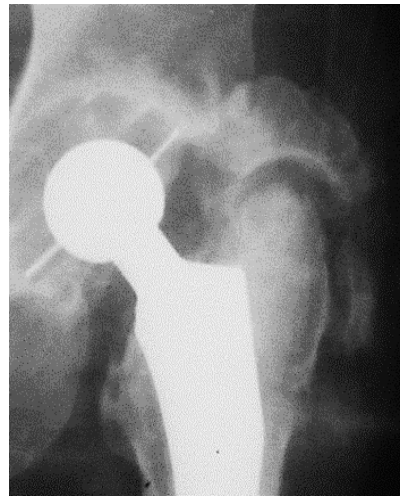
Left hip X-ray showing 3rd degree heterotopic ossification.*
